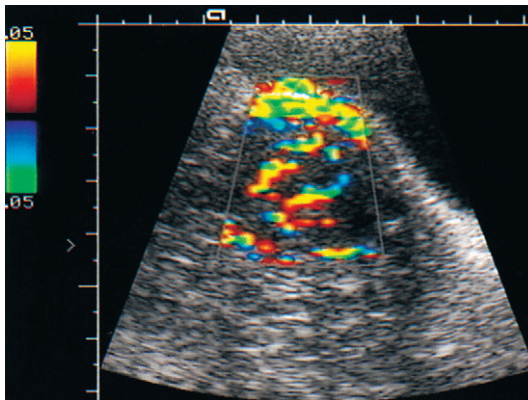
Transabdominal ultrasound of the uterus with abnormal flow demonstrating gross hyperaemia extending to the surface of the uterus in an endometrial carcinoma with extensive myometrial invasion.
